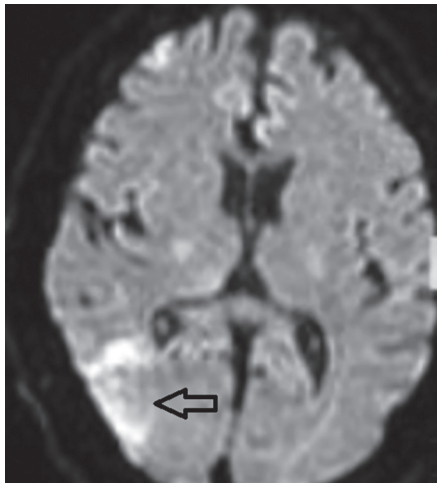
Magnetic resonance imaging brain with hyperintensities in right high parietal region suggestive of acute ischaemic infarcts in a watershed area
